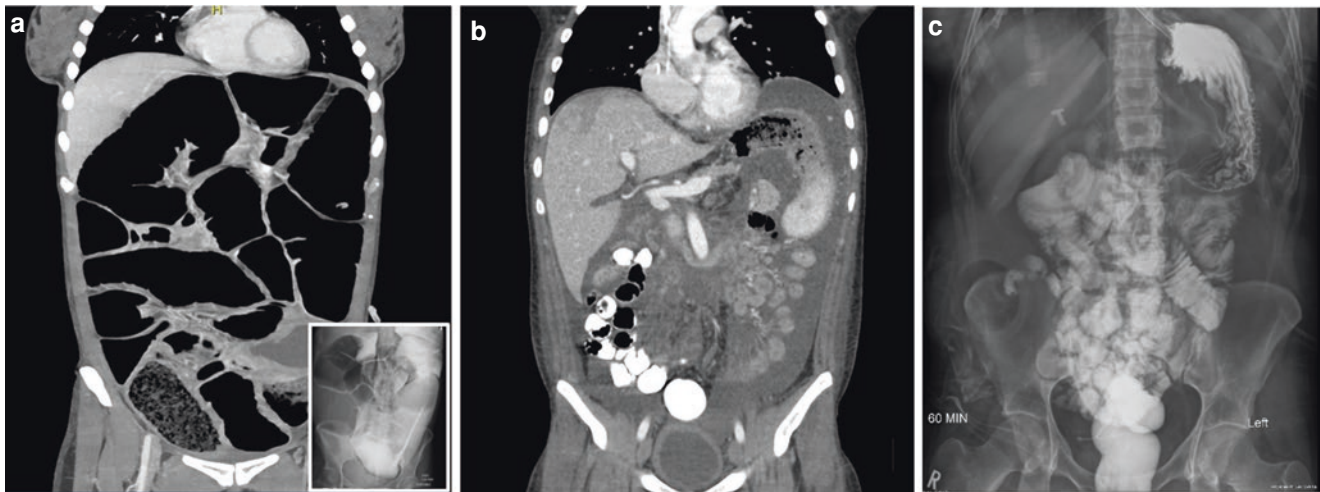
Global gut dysmotility and gut transplantation. (a) Abdominal CT and gastrografin follow-through (insert) showing massive dilation of the small and large bowel defining the classic roentgenographic features of chronic intestinal pseudo-obstruction (CIPO) as a common variant of gut dysmotility. (b) CT imaging of a modified
